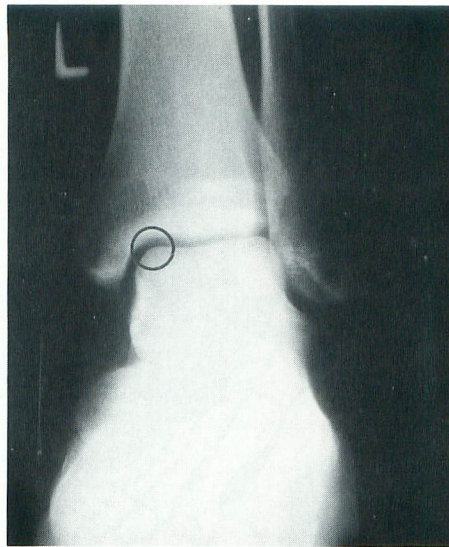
AP X-ray showing no pathological result.
